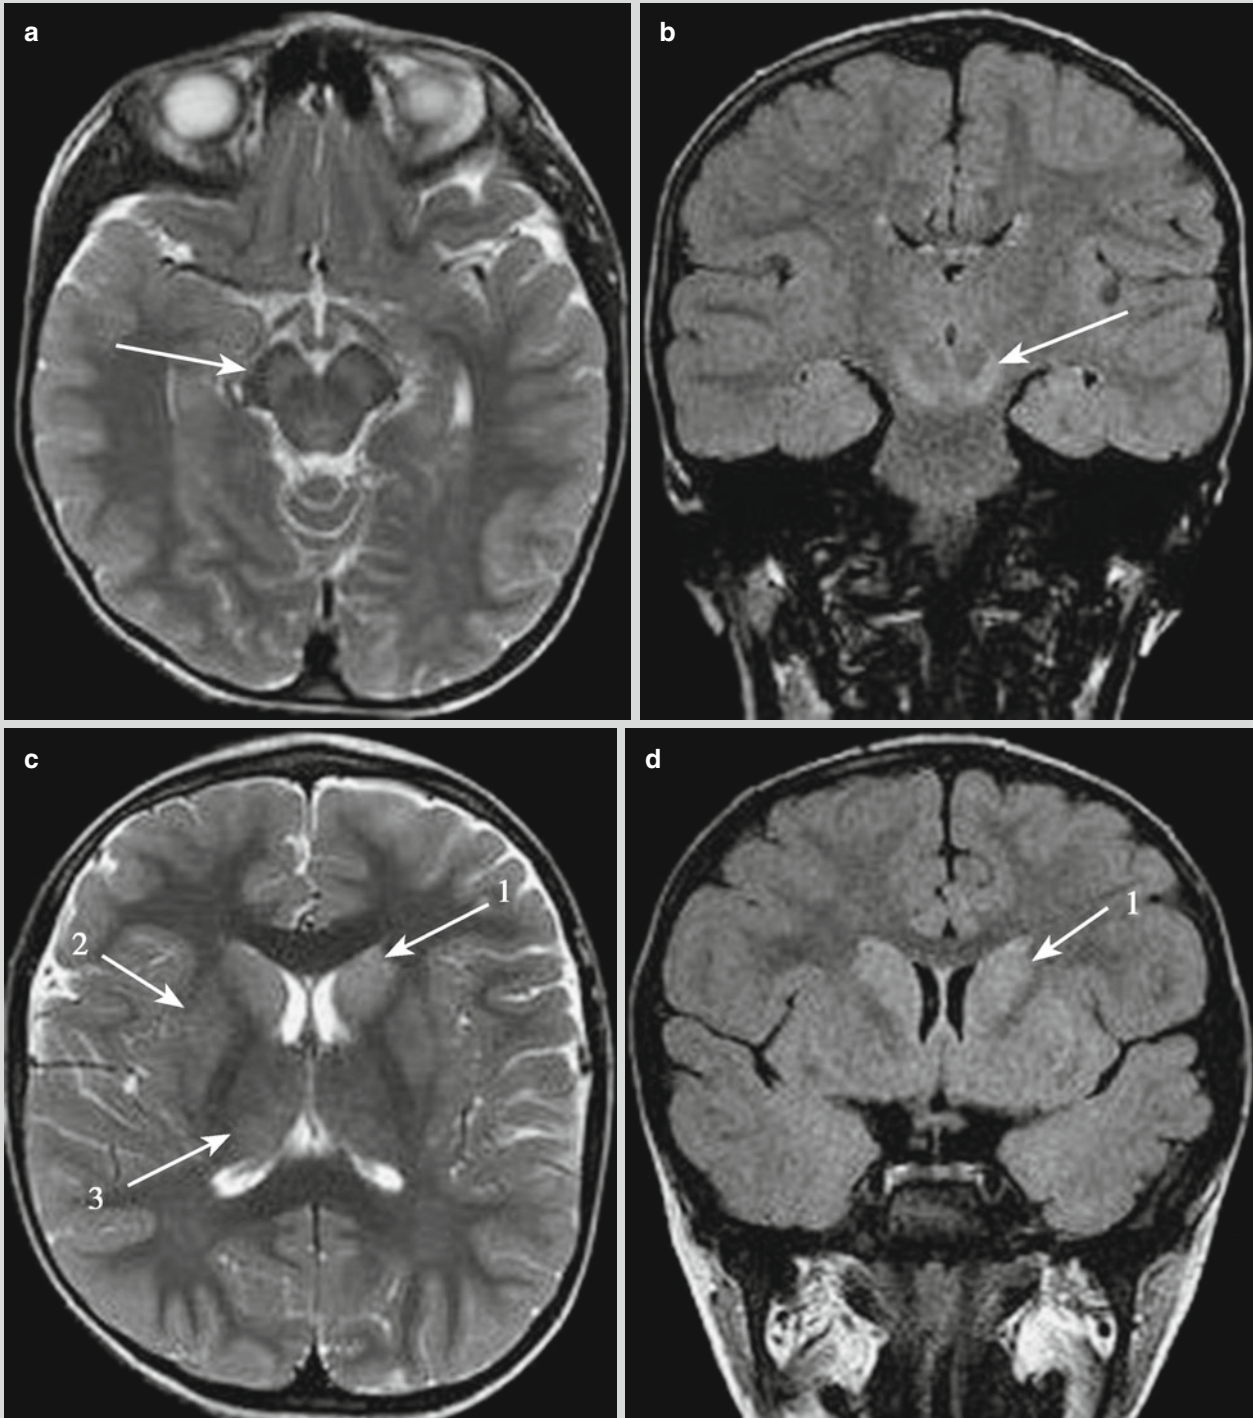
Hemolytic uremic syndrome. (a, c) Transverse T2WI demonstrations. (b, d) Coronal FLAIR demonstrations. (a, b) High signals are demonstrated at the bilateral pedunculus cerebri (indicated by *arrows*). (c, d) Slightly high signals are demonstrated
